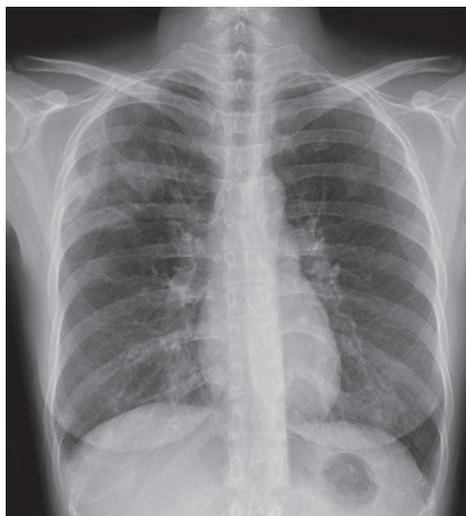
Chest radiography on presentation to the hospital
